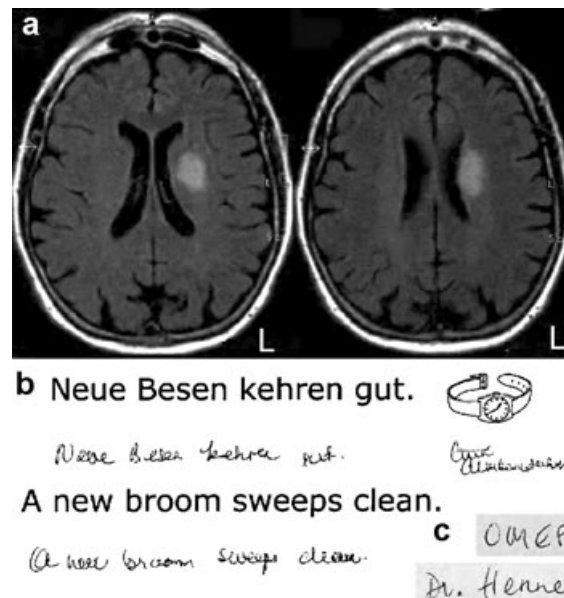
a) FLAIR-weighted MR images, b) sample of the patient's handwriting, c) sample of the patient's premorbid handwriting.
